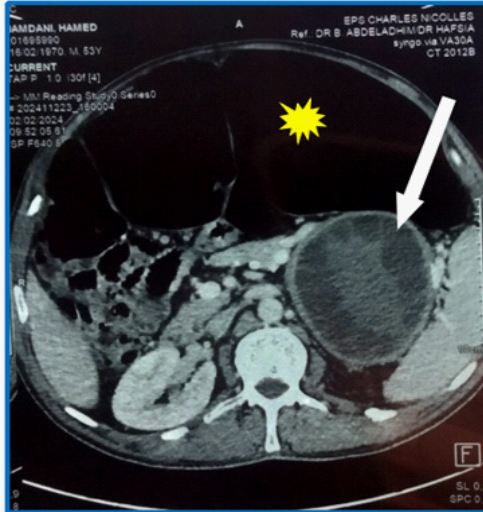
Axial contrast-enhanced abdominal CT showing colonic distension (*) and a multilocular pancreatic cyst (white arrow).
